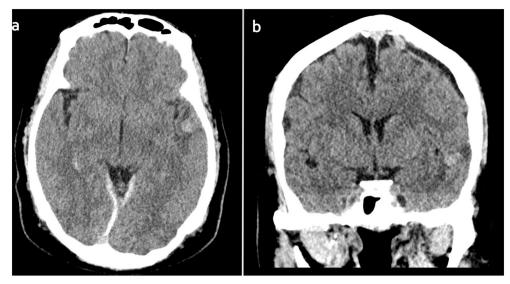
Transaxial [a] and coronal [b] unenhanced CT scan of the brain, exhibits a well-defined intra-axial hyperattenuated lesion in the left temporal lobe with mild perilesional edema. There is bilateral subdural hyperattenuation overlying the tentorium cerebelli, which represents a subdural hemorrhage [a].
